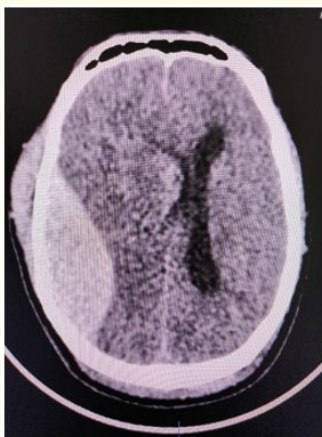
(a): CT scan of the same patient showing a large lenticular-shaped hyperdensity in the right parietal region in the extradural location, causing a significant midline shift towards the left side, suggestive of an extradural haemorrhage. A hypodensity is noted in the right parietal lobe adjacent to the above-mentioned hyperdensity, suggestive of brain edema.
